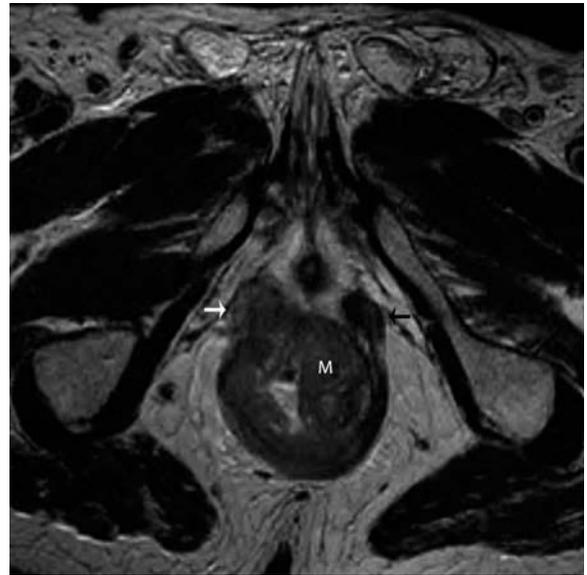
Stage T3 rectal carcinoma in a 55-year-old male. Axial T2-weighted image shows an intermediate T2 signal intensity rectal mass (M) with extension into the right puborectalis muscle (white arrow). Normal left puborectalis muscle (black arrow).
